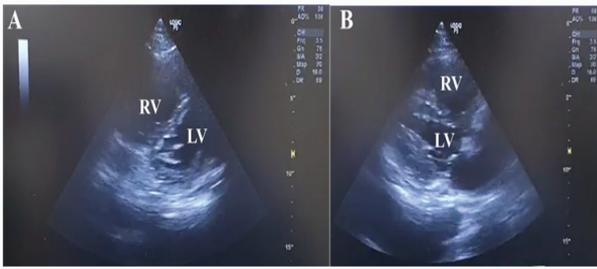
Point-of-care echocardiogram in a case of suspected pulmonary thromboembolism demonstrates the flattening of the interventricular septum (D-shaped left ventricle) and right ventricle enlargement on a parasternal short axis view (A) and parasternal long axis view (B). LV: Left Ventricle; RV: Right Ventricle
